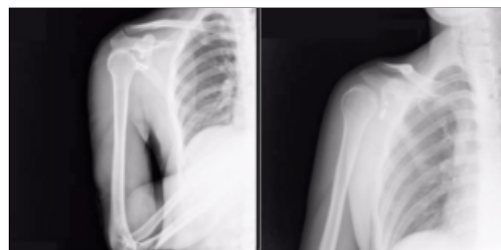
X-ray image of soft tissue injury.
